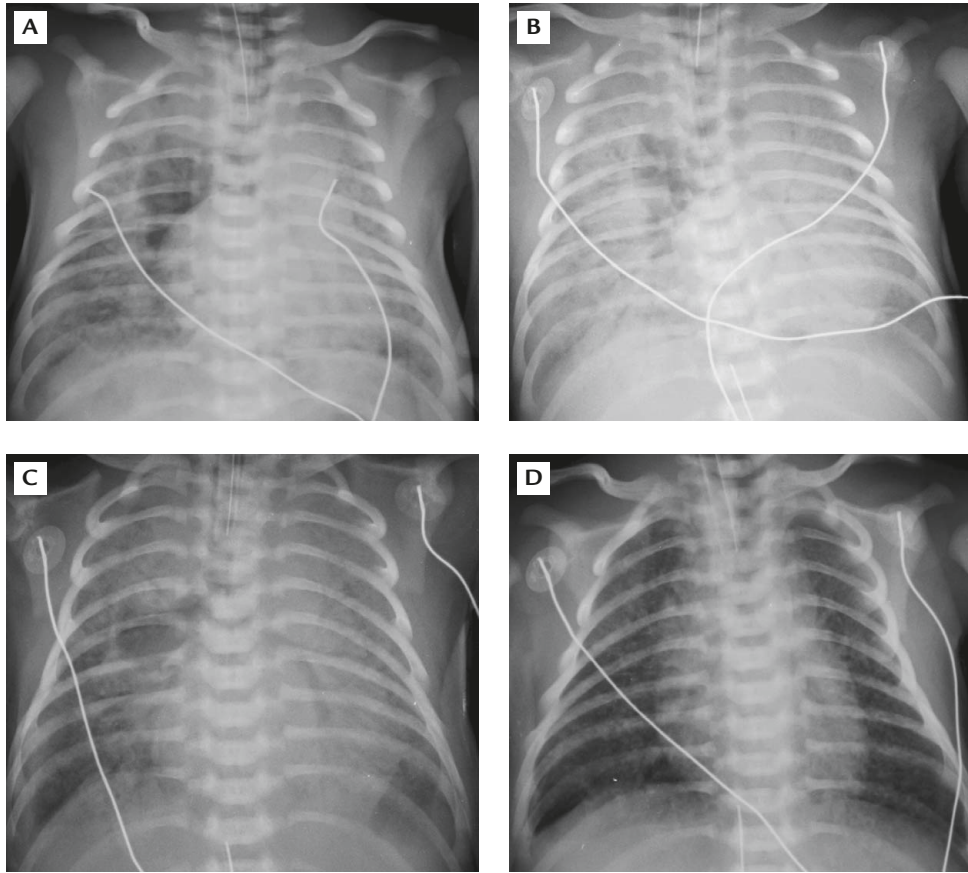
Chest X-ray of Case 2: (A) before lavage; (B) 2 hours after lavage, before chest tapping; (C) 5 hours after lavage, after chest tapping; (D) 24 hours after lavage.
